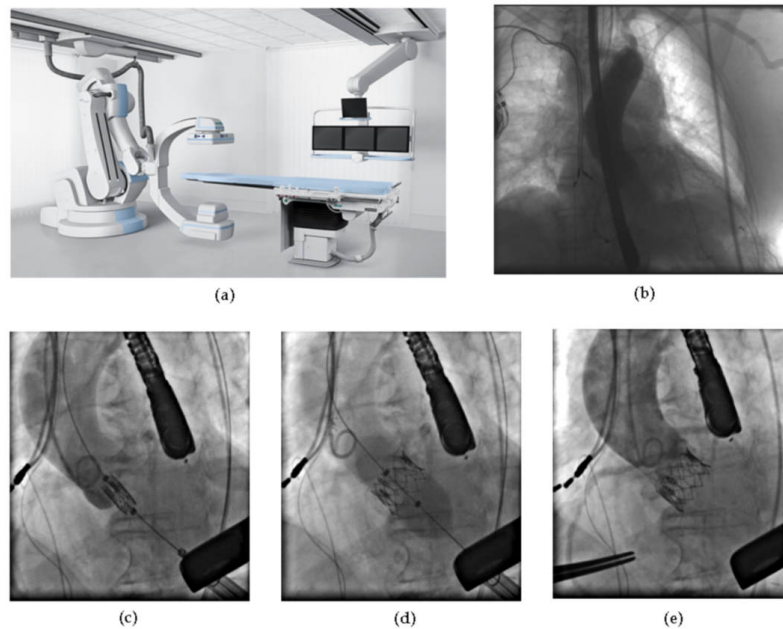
(a) Fluoroscopy C-arm system (Siemens Artis Zeego, Forchheim, Germany). (b) Dyna-CT image. 2-D Fluoroscopy guidance during the TAVI procedures: (c) Valve positioning, (d) Valve implantation, and (e) Final assessment after valve implantation.
